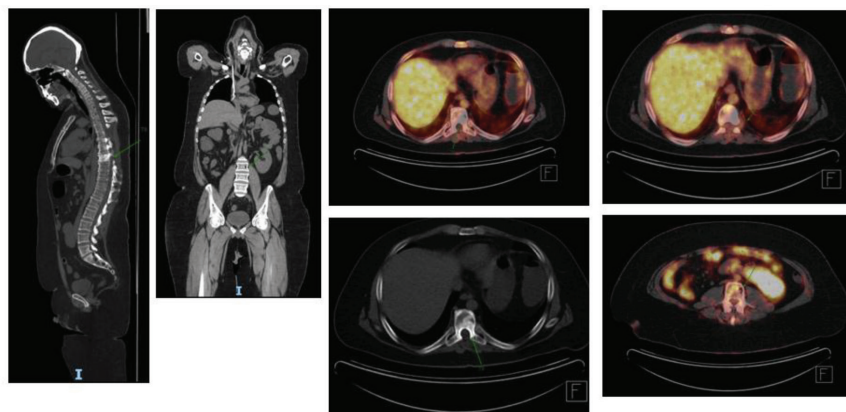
PET/CT scan on 9 April 2021 showed stable small residual left paravertebral mass adjacent to T7, 8 vertebral bodies, 1 cm in diameter, SUVmax =2.74 (previous 0.9 cm SUVmax=3.03, Score 2, complete metabolic response).
